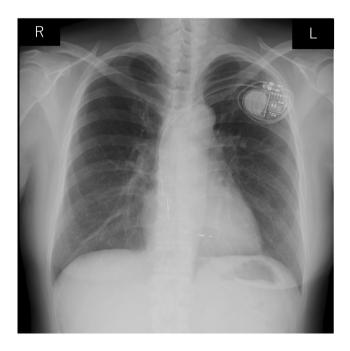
Chest radiography after dual-chamber pacemaker implantation.
